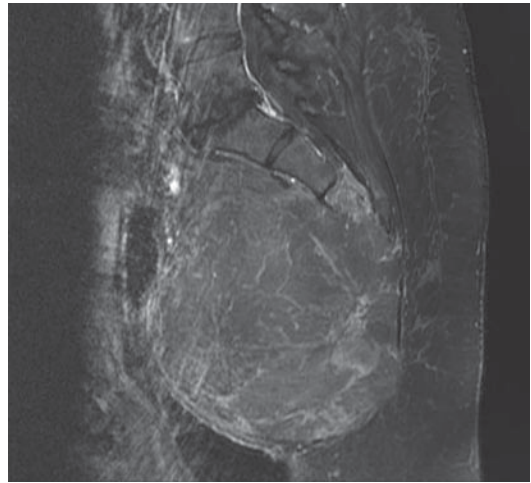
MRI of sacral chordoma with crisscrossing septa in tumor and destruction of S3 vertebra.
